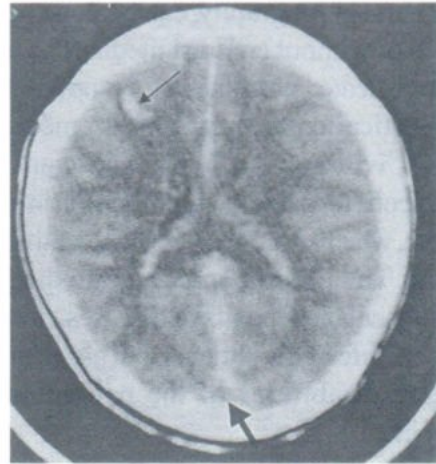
CT. show petichial hemorrhage at frontal lobe as indicated by small black arrow. There is also thrombus in the superior sagittal sinus as indicated by thick, short arrow called delta sign or empty triangular sign. "delta sign" is a special name for superior sagittal sinus thrombosis.
